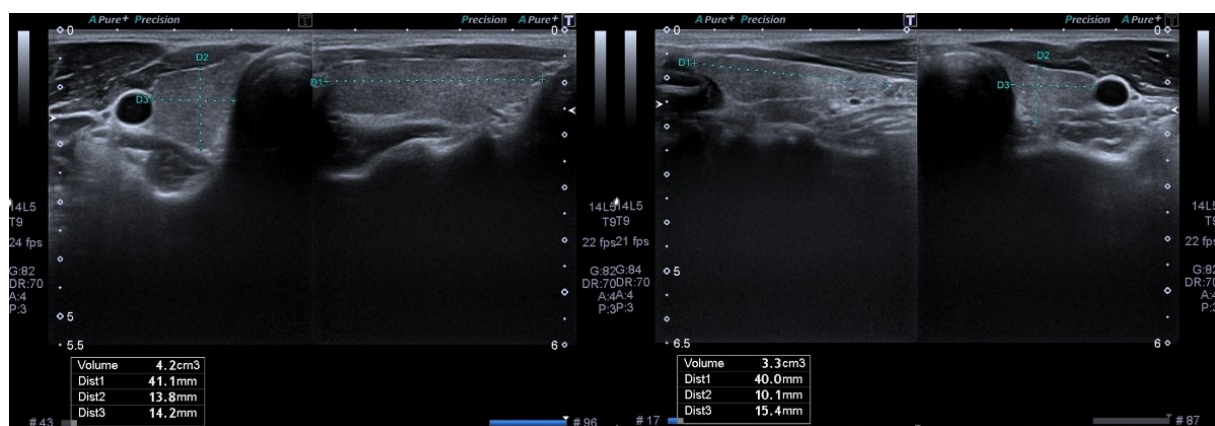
Ultrasound image of thyroid volume of a 40-year-old female adult.
